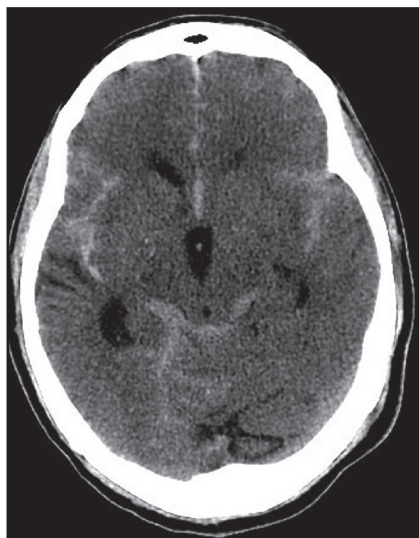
Noncontrast CT demonstrating diffuse SAH in the interhemispheric fissure, bilateral MCA cisterns, and bilateral ambient cisterns. No IVH was noted.
